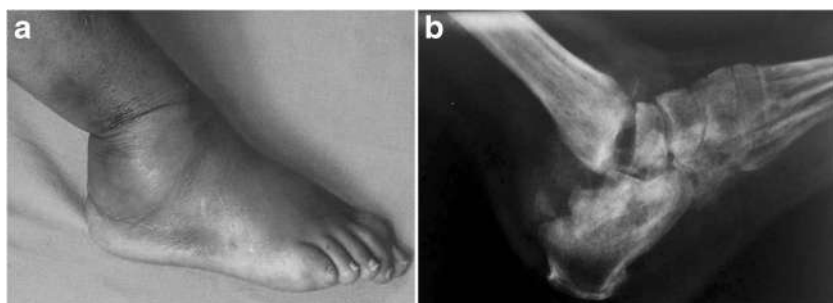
a Clinical photograph showing swelling and deformity of left ankle and hindfoot. b X-ray of the right foot (lateral view) showing features of Charcot neuroarthropathy of the ankle in the form of partial
